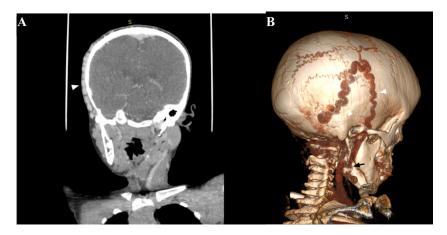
Coronal soft tissue window contrast enhanced head and neck CT (A) and angiographic 3D volume rendered images (B) - tortuous, homogeneously, and avidly enhancing right scalp vascular structures (white arrowhead). Black arrow in B shows communication with a right internal jugular vein.
